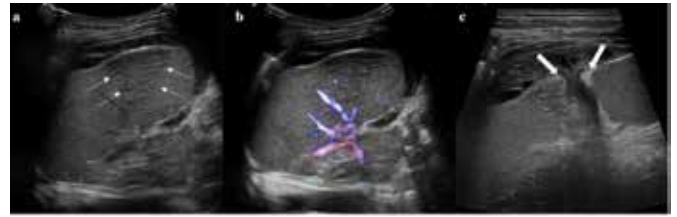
Gray scale ultrasound (“a”), transabdominal Doppler examination technique (“b”) and presence of rupture of the splenic capsule (“c”)<sup>12</sup>.
